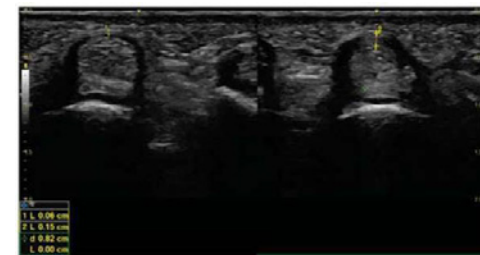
A short-axis ultrasound image of the A1 pulley in a physiological situation (left) and in a pathological situation (right) in which the fibrous thickening characteristic of trigger finger is visible and measurable.
